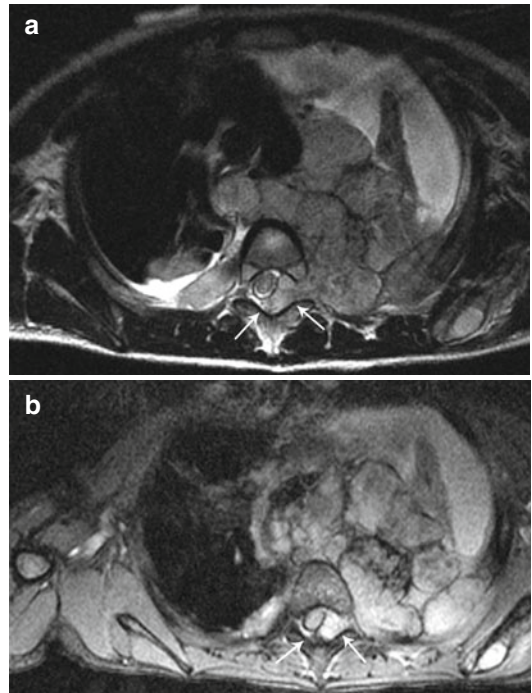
Neuroblastoma. Axial MR images (a, b) in a 5-year-old boy with a large posterior mediastinal neuroblastoma demonstrates evidence of tumor extension into the spinal canal (arrows) with associated displacement and compression of the spinal cord
